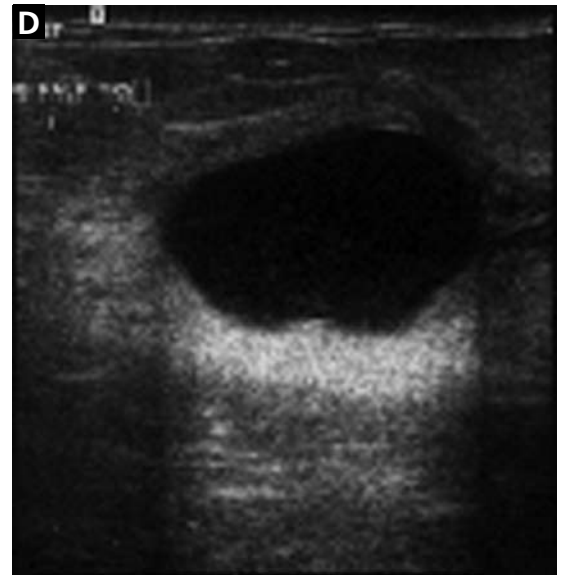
A simple cyst in the left breast. All three mammographic views—cranio-caudal (A), mediolateral oblique (B), and spot-compression (C)—show a round, well-circumscribed mass in the mid-breast. Ultrasonography (D) shows a round, well-circumscribed anechoic lesion with a sharply defined posterior wall and posterior acoustic enhancement.
